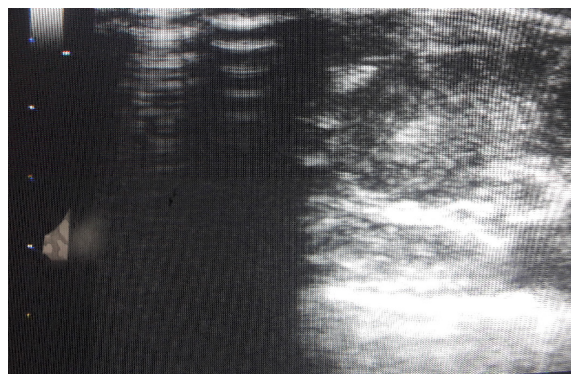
Sonographic location of the lymph node. Source: Doctor Andrés Ignacio Chala Galindo's file.
